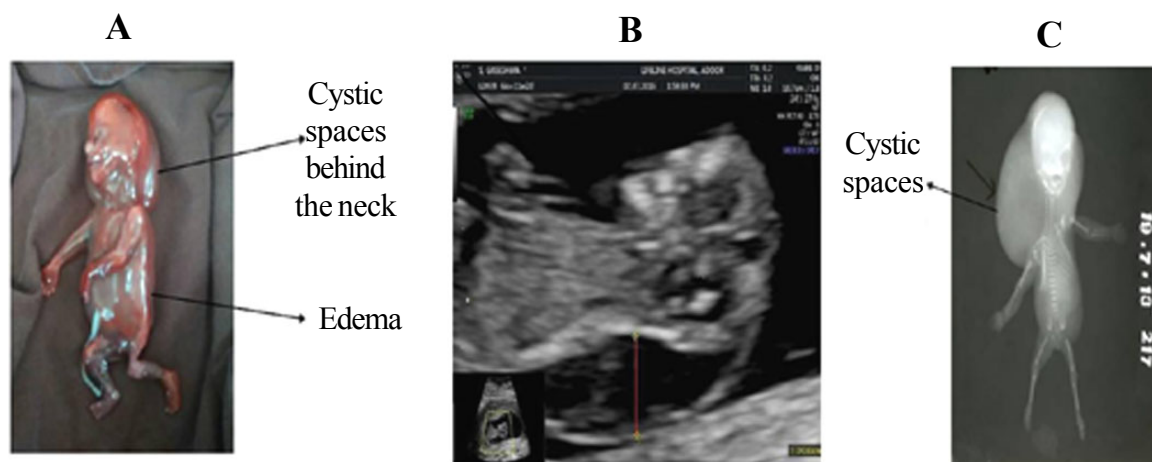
Figure A) Fetus with cystic hygroma after MTP B) Ultrasound image of a fetus with cystic hygroma C) X-ray image of fetus with cystic hygroma
